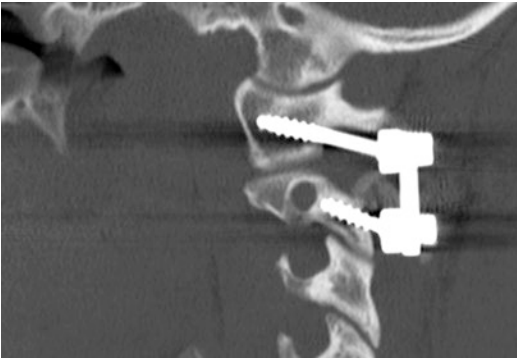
CT scan of a patient who underwent C1-C2 Harms construct. Note the pars screw at C2 and how it stops short of the vertebral artery
